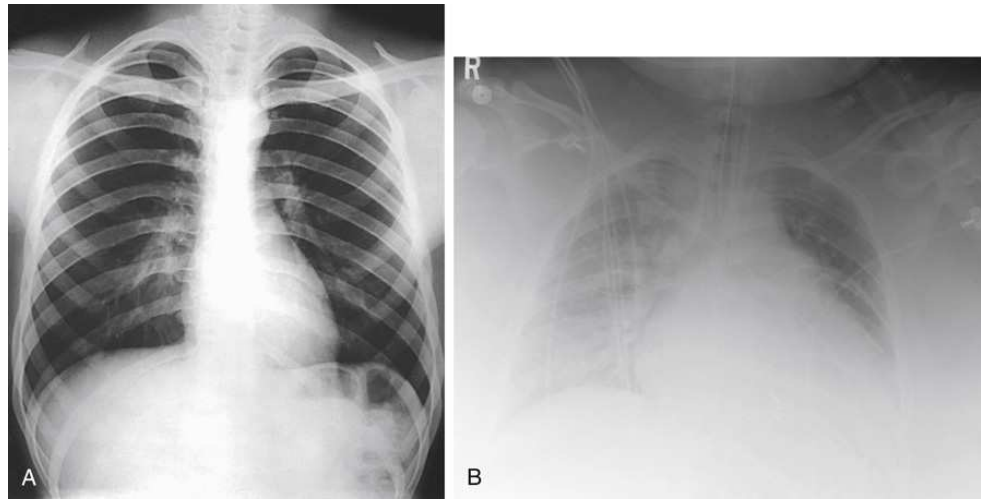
(A) Chest radiograph on a 160-lb patient. Note very good contrast and visibility of structures. (B) Chest radiograph on a 360-lb patient. Note reduced contrast and fogging on the image. However, a reasonable image was obtained.
